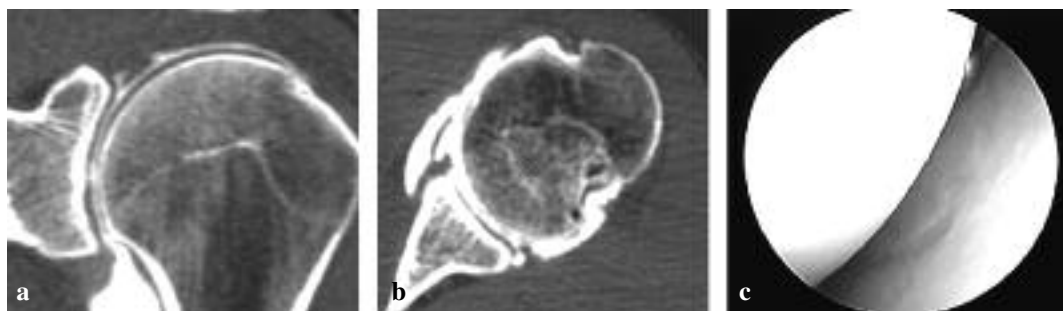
Representation of bare spot. a, b : MDCTA view ; c : arthroscopic view (MDCTA = Multidetector CT arthrography)
